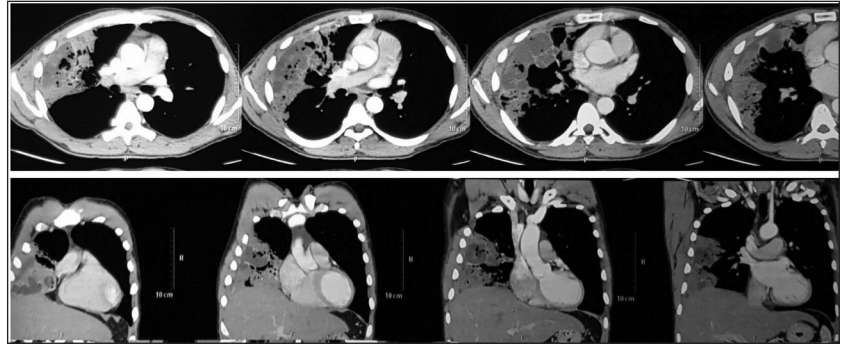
CT chest showing area of consolidation with air bronchogram
